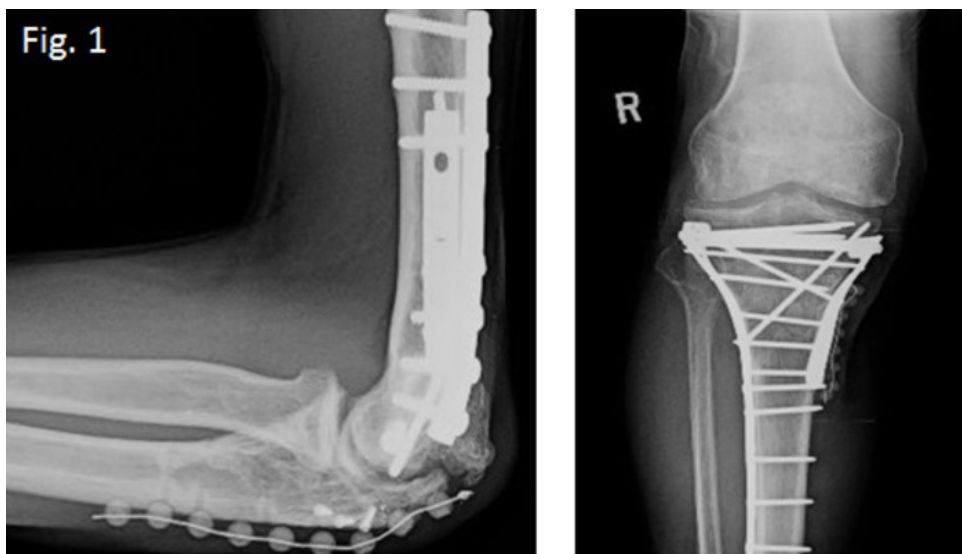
Radiographs of patients who had symptomatic beads. Patient on left had beads placed posterior to proximal ulna. Patient on right had beads placed on medial face of tibia.
